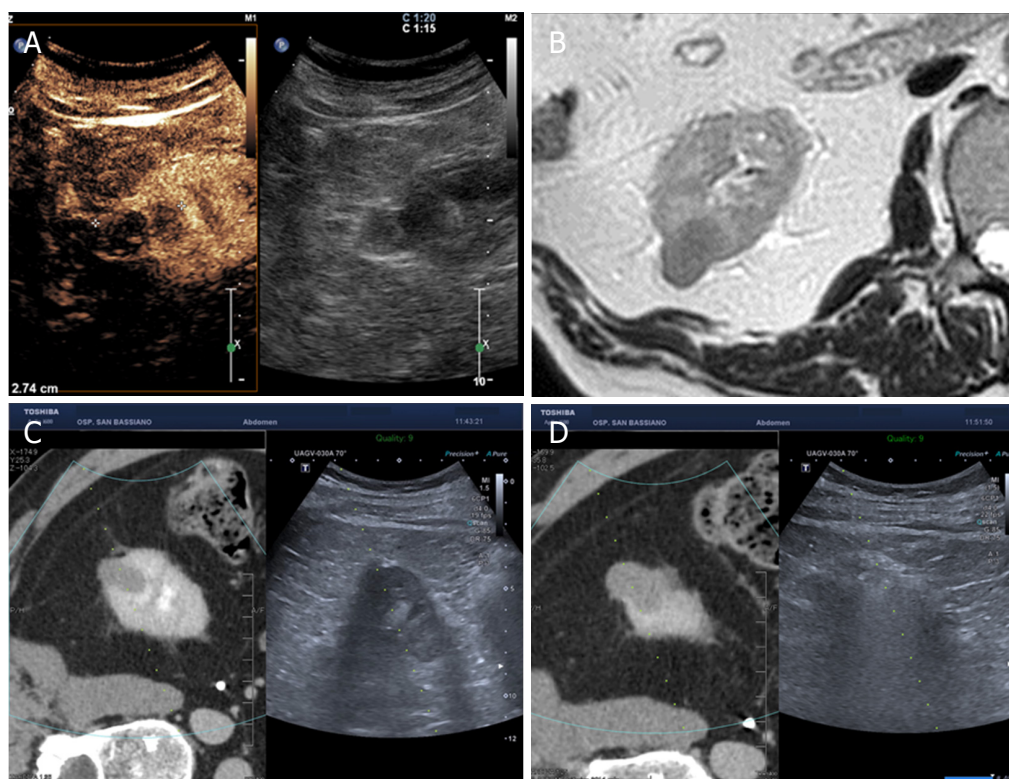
Fusion-guided microwave ablation. 75 years old patient with exophytic in the right kidney, identified by sonography and contrast-enhanced ultrasound (A) and confirmed by MR (B), it was a RCC (biopsy proven) treated with microwaves through guided fusion technique (C-D). RCC: renal cell carcinoma
